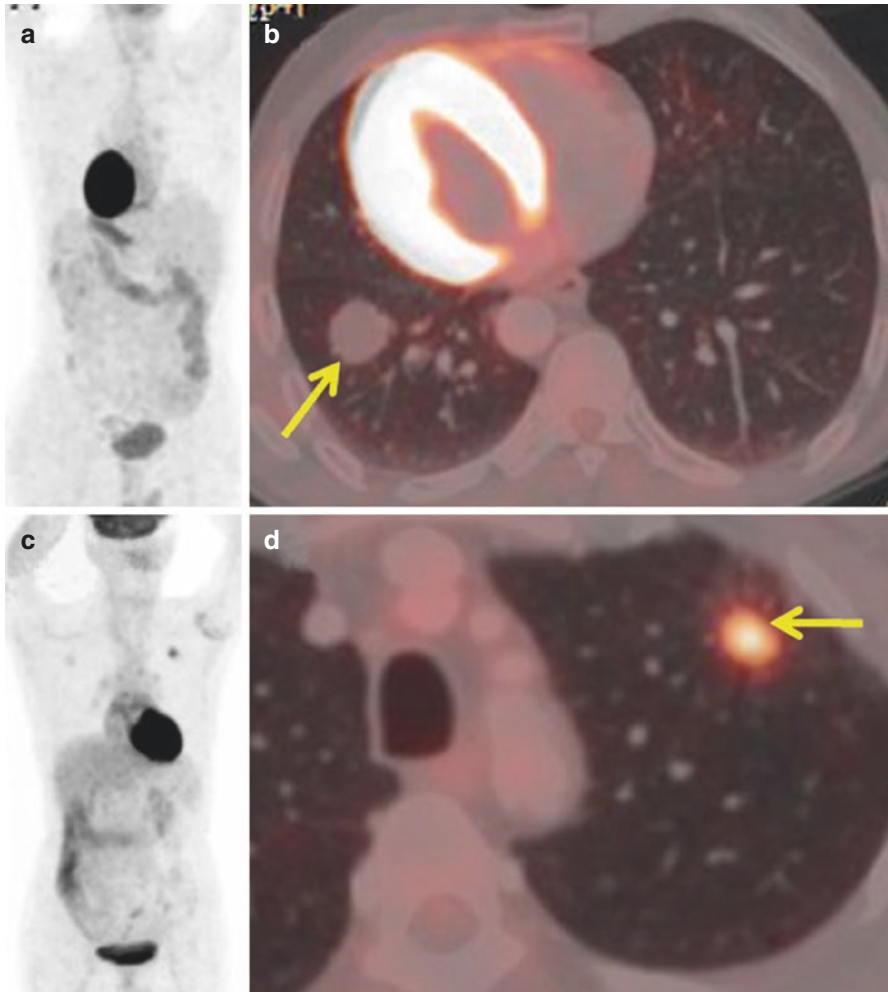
(a, b) A patient of situs inversus being evaluated for a solitary pulmonary nodule (SPN). No FDG uptake in the SPN in the lower lobe of right-sided lung (arrow). No metabolic activity indicates the possibility of a benign lesion which was confirmed by biopsy. (c, d) Hypermetabolic SPN in the upper lobe of the left lung (arrow)—likely to represent a malignant lesion. Biopsy was adenocarcinoma confirming the PET/CT finding
